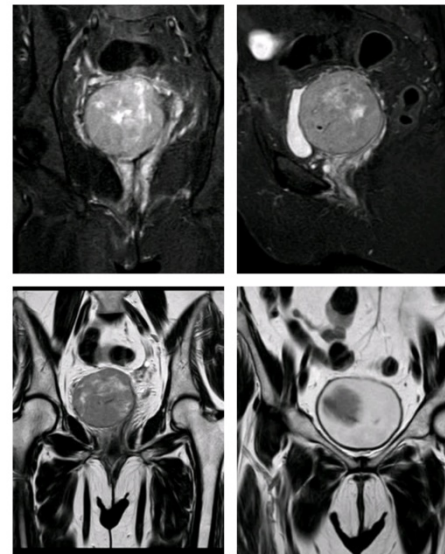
MRI (Abdomen with Pelvis) plain and contrast
